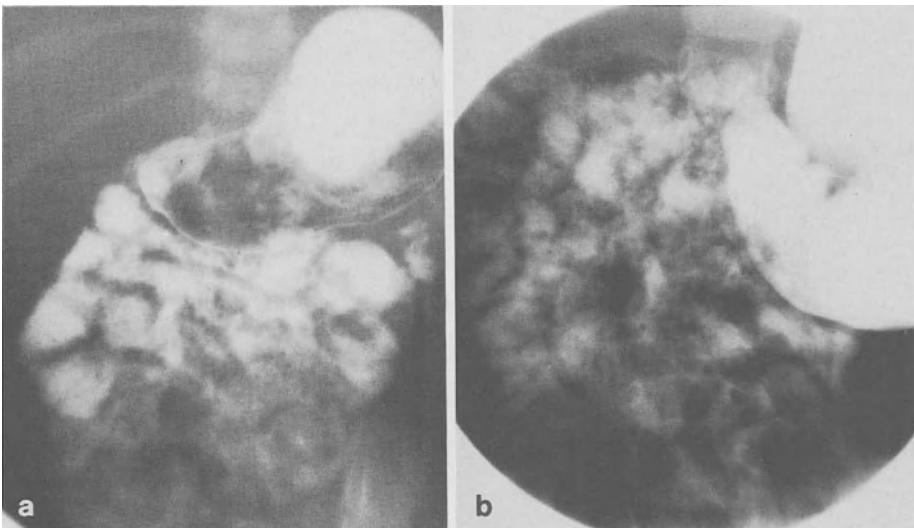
Postoperative gastrointestinal X-ray control after fibrin plication in an infant. After 1 week (a) an 3 weeks (b)
